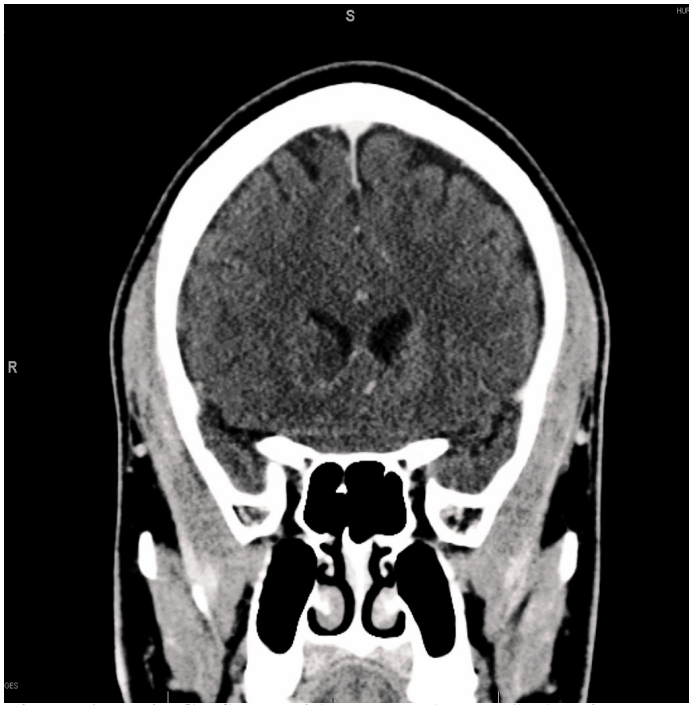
Brain CT-Scan with contrast (coronal) showing mass-like heterogeneous enhancement in the right caudate nucleus with mild extension to the periventricular white matter.
